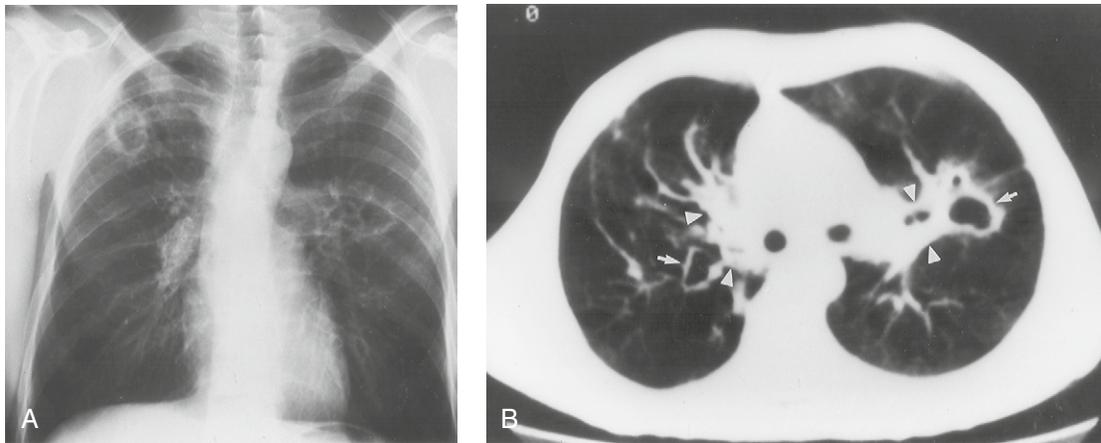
A 40-year-old white man with known sporotrichosis who had continued symptoms despite treatment with ketoconazole. (A) PA chest radiograph shows fibrocavitary disease involving the right upper lobe and the superior segment of the left lower lobe. A right upper lobectomy was subsequently performed revealing sporotrichosis. (B) Chest CT (lung windows) demonstrates a thin-walled cavity in both upper lobes (arrows). Marked thickening of the interstitium surrounding hilar bronchovascular structures is present bilaterally (arrowheads).
